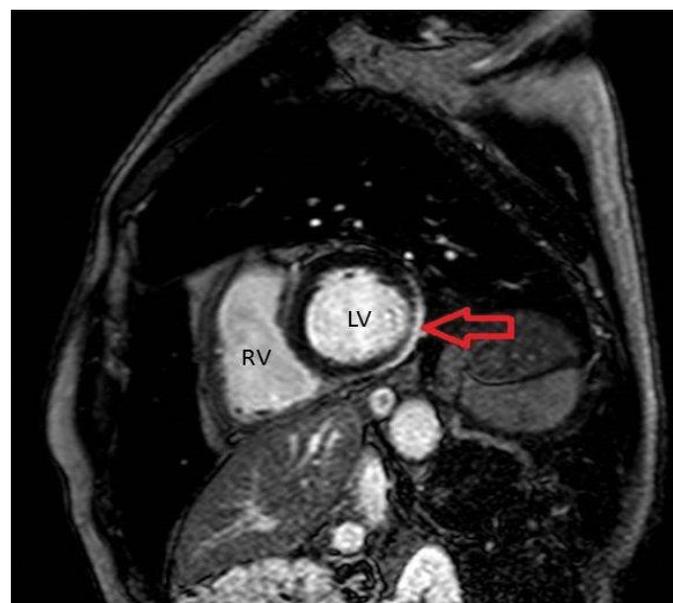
Cardiac magnetic resonance image of case 4, short axis
